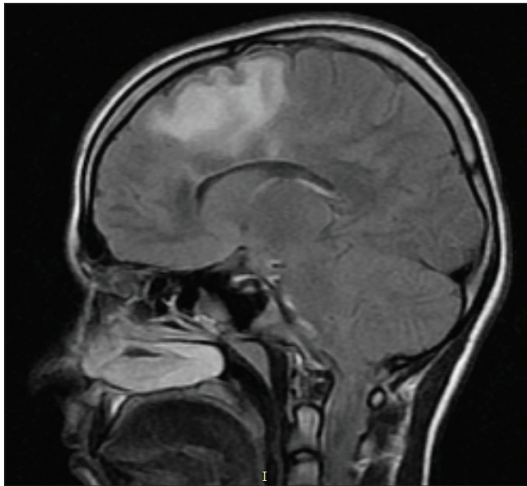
Thirteen-year-old female patient with seizure presentation. On MRI FLAIR sequence shows a huge hyperintense perilesional edema along with right frontal lobe above corpus callosum.
